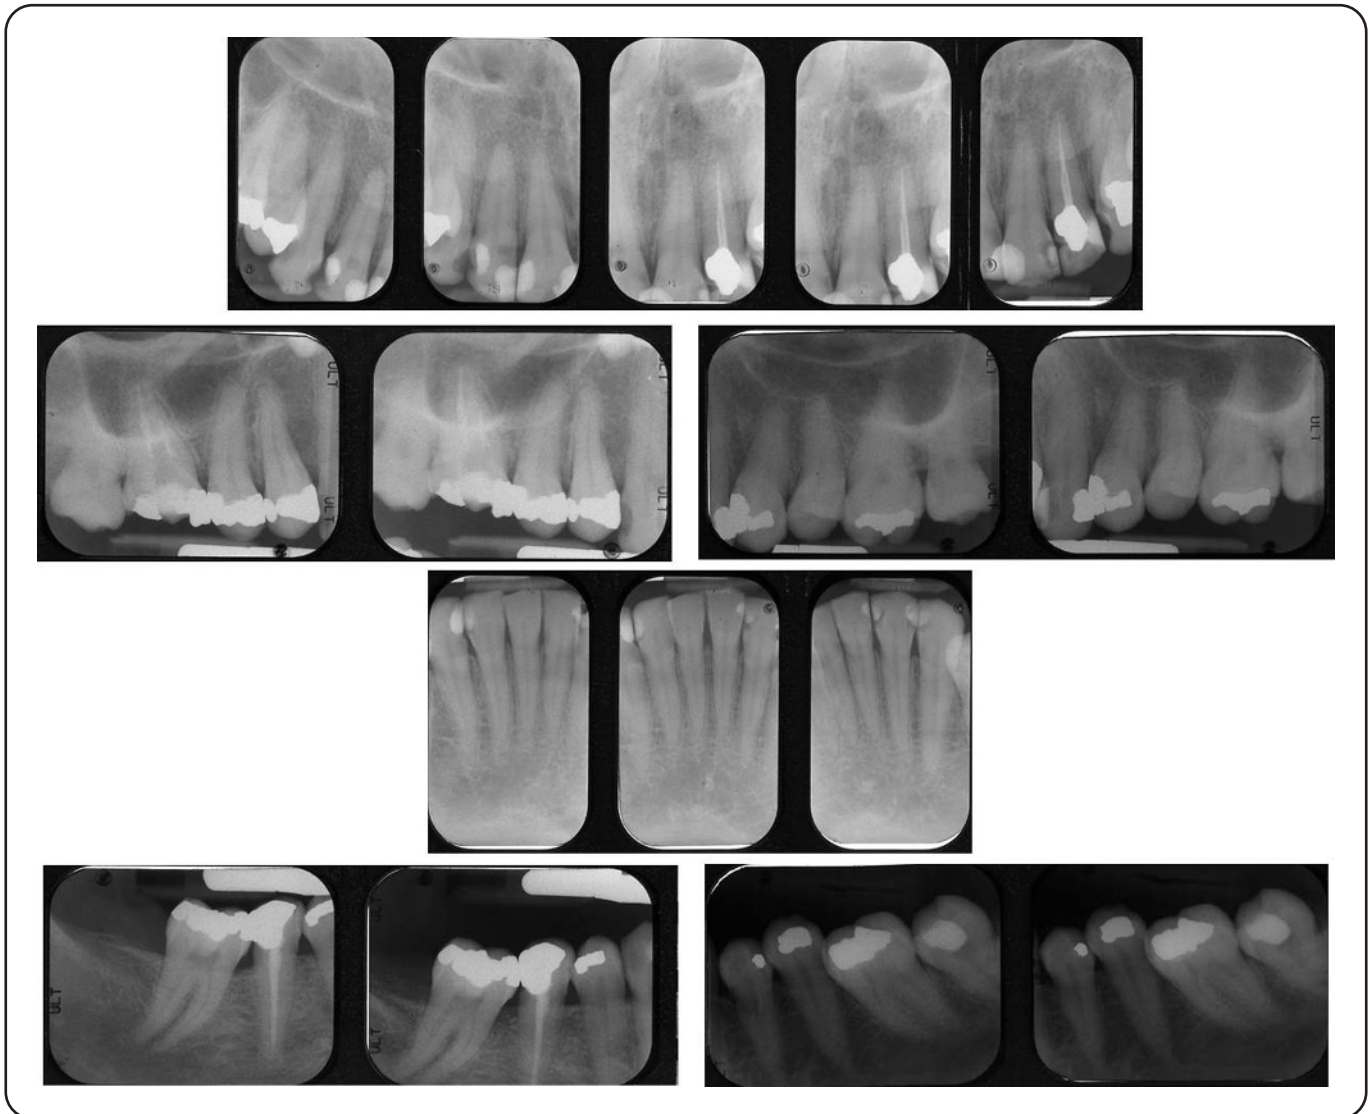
Peri-apical radiographs depicting the interproximal bone levels.
